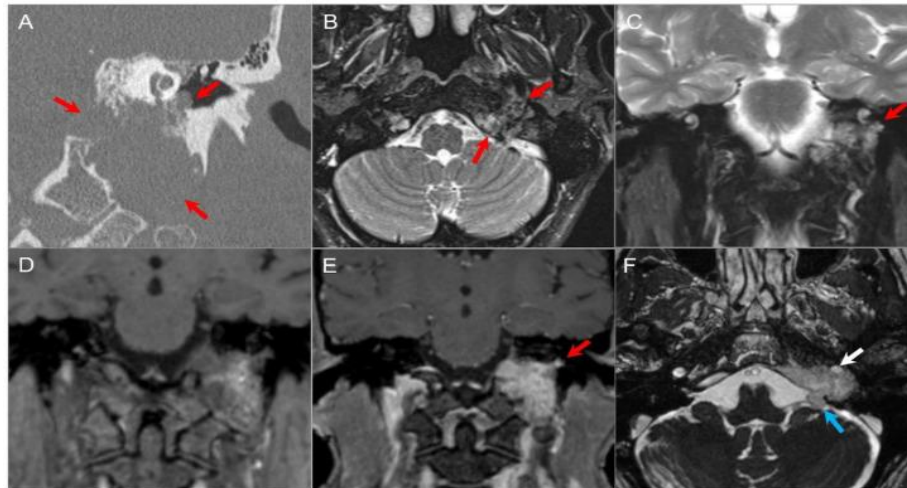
Glomus jugulotympanicum. (A) Coronal CT image demonstrates a soft tissue density lesion in the left jugular fossa with irregular moth-eaten osseous erosion. The mass extends into the middle ear cavity at the cochlear promontory (red arrows), confirming a combined glomus jugulotympanicum. (B) Axial and (C) coronal fat-suppressed T2W images demonstrate heterogeneous hyperintense signal in the lesion (red arrows) with tiny signal voids consistent with hypervascularity. (D) Coronal noncontrast T1W image demonstrates a 'salt and pepper' appearance with small foci of hyper- and hypointensity. (E) Coronal postcontrast T1W image shows avid enhancement of the lesion (red arrow). (F) Axial postcontrast CISS image reveals partial encasement of the left ICA (white arrow) and polypoid extension of the lesion into the left CPA cistern (blue arrow) due to dural disruption (Rao *et al.*, 1999; Rigby & Jackler, 1996).
